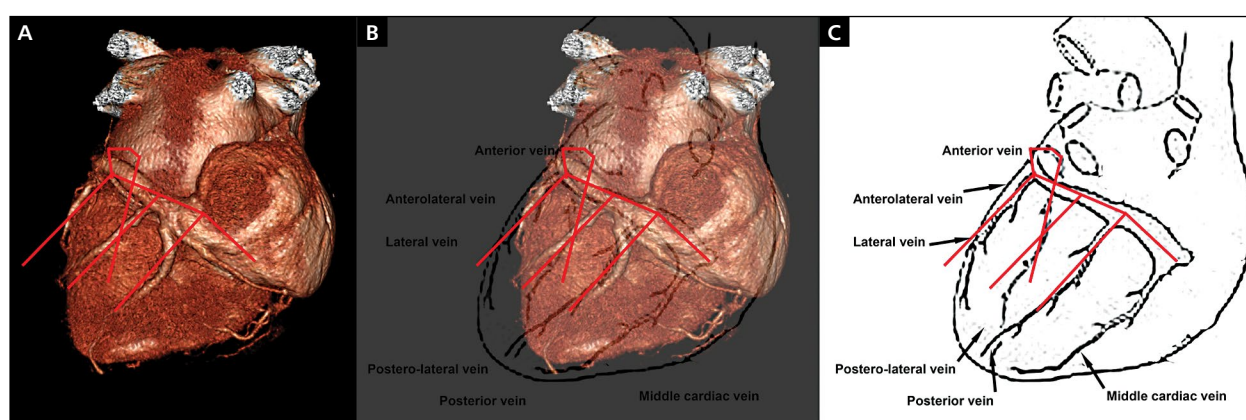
Example of the coronary venous system (variant C3PLA11) — multi-slice computed tomography three-dimensional volume rendering image (A), the scheme and superimposition of both images (B); C. Scheme of coronary venous system
